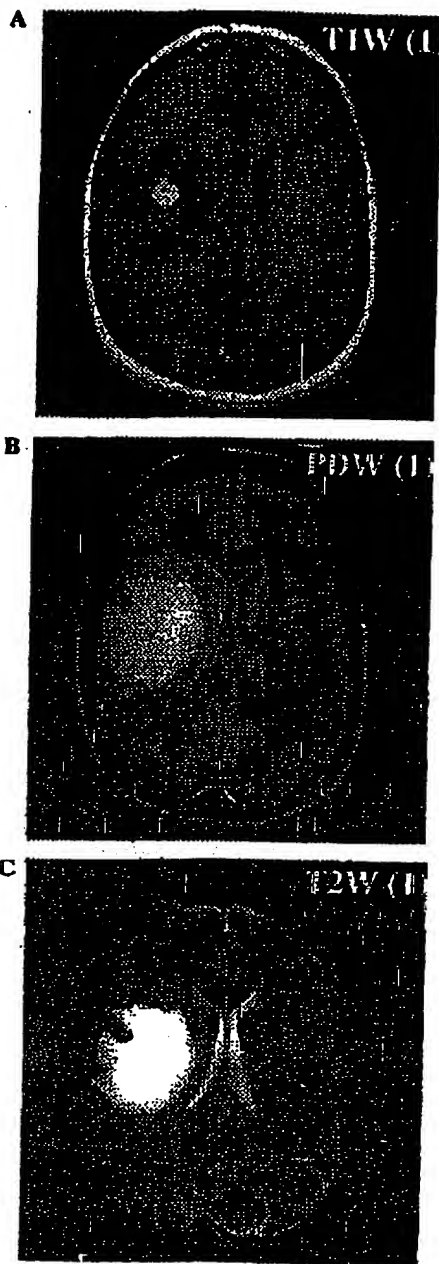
MRI scans used to evaluate degree of edema in each patients; (A) typical axial MRI T1 weighted (TIW) image: the light area is the tumor and the slightly darker area around it is the edema; (B) proton density weighted (PDW) image; (C) T2 weighted (T2W) image.
